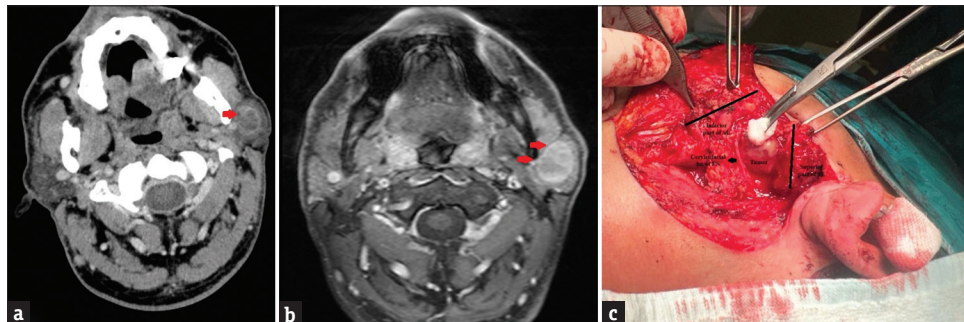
Selective deep-lobe parotidectomy with the superficial lobe splitting technique. (a) Axial CT image showing a heterogeneously contrast-enhanced lesion in the deep lobe of the parotid gland, (b) Axial T1-weighted gadolinium-enhanced MRI image showing a deep-lobe lesion with peripheral and septal contrast enhancement, (c) The superficial lobe was divided into two parts (superior and inferior) along the line of the main trunk of the facial nerve (black lines)
